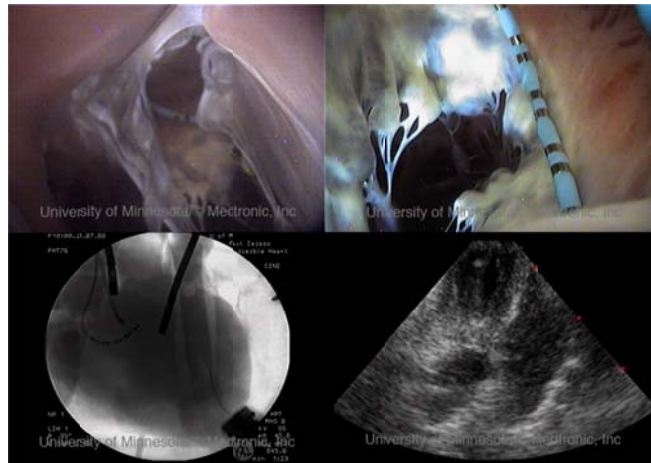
The tricuspid valve imaged using: 1) an endoscope placed within the right ventricle (upper left panel); 2) an endoscope placed within the right atrium (upper right panel); 3) fluoroscopy with an anterior-posterior orientation (lower left panel); and 4) ultrasound (lower right panel). Modified from “The Atlas of Human Cardiac Anatomy” [30].
